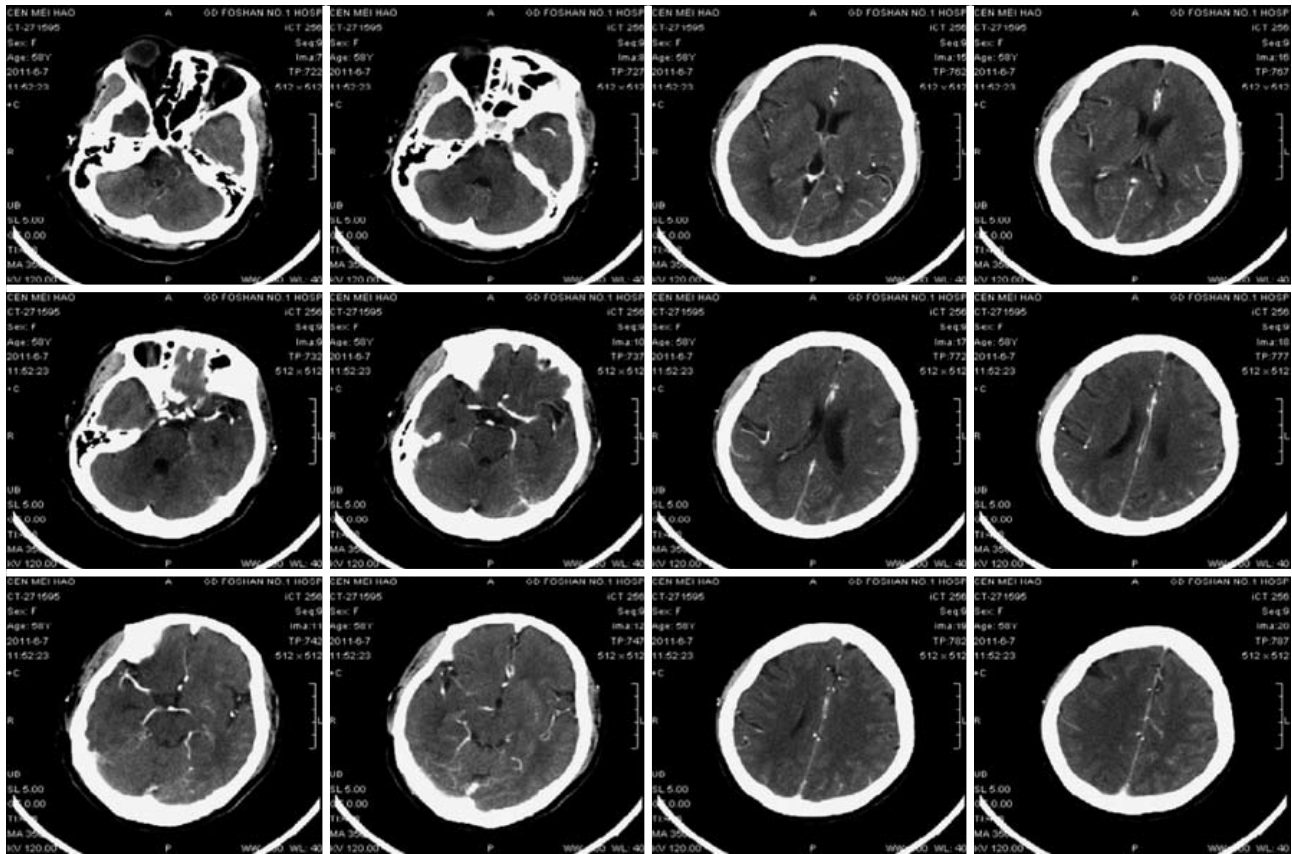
Repeat enhanced computed tomography and magnetic resonance venography scan of the brain of case 2 on the following day showed the same image changes as previously described.
